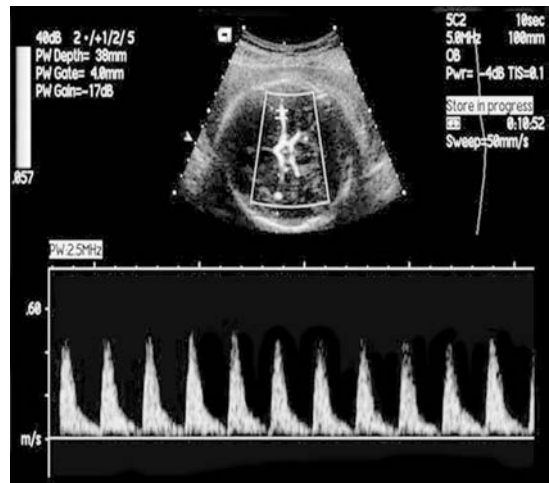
Doppler velocimetry of the middle cerebral artery
